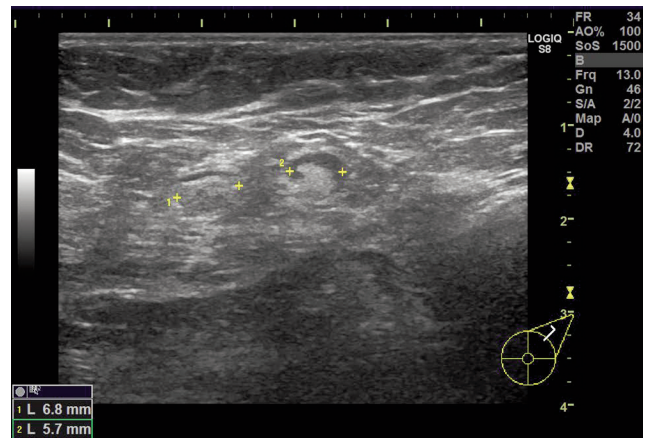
Ultrasonography (December 2021) shows an axillary lymph node of 5.7 mm length with a cortex thinner than that observed in June 2021. The cortex was still slightly thick.
